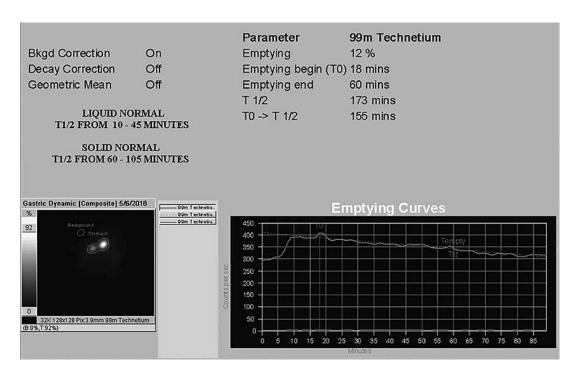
Gastric emptying scintigraphy: there was no evidence of gastroesophageal reflux during 90 min of continuous observation. Gastric half-emptying time was 173 min. Delayed gastric emptying suggested gastroparesis.
